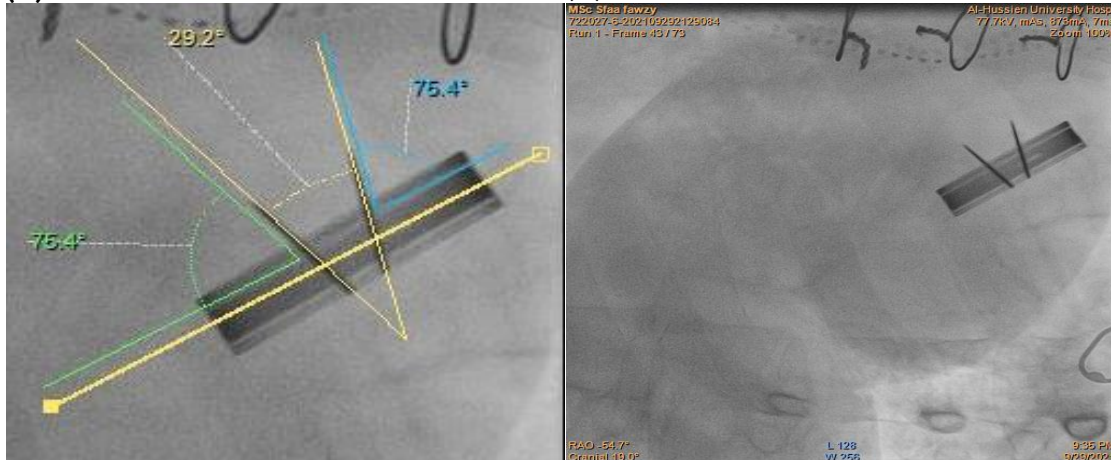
Figure I): (A, B) CT measurement of prosthetic aortic valve for a selected study case (Opening angle (OA)°, 1st Occluder angle OA° and 2nd Occluder angle OA° (Lt. panel). Closing angle (CA) °, 1st angle CA° and 2nd Occluder angle CA° (Rt.
